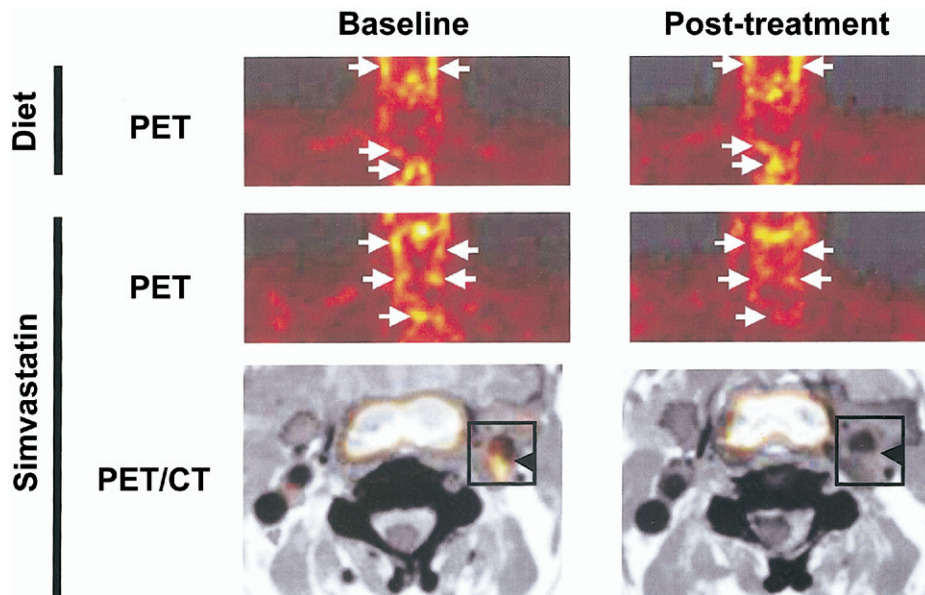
Effects of simvastatin on ¹⁸F-DG uptake in atherosclerotic plaque inflammation. Representative ¹⁸F-DG-PET images at baseline and after 3 months of treatment (post-treatment) with dietary management alone (diet) or simvastatin. (Top) Dietary management alone had no effect on ¹⁸F-DG uptakes (arrows) in the aortic arch and the carotid arteries. (Middle) ¹⁸F-fluorodeoxyglucose uptakes were attenuated by simvastatin treatment. (Bottom) The co-registered images of ¹⁸F-DG-PET and CT clearly show that the plaque ¹⁸F-DG uptakes (arrowheads) disappeared after 3-month treatment with simvastatin. Abbreviations as in Figure 1.
